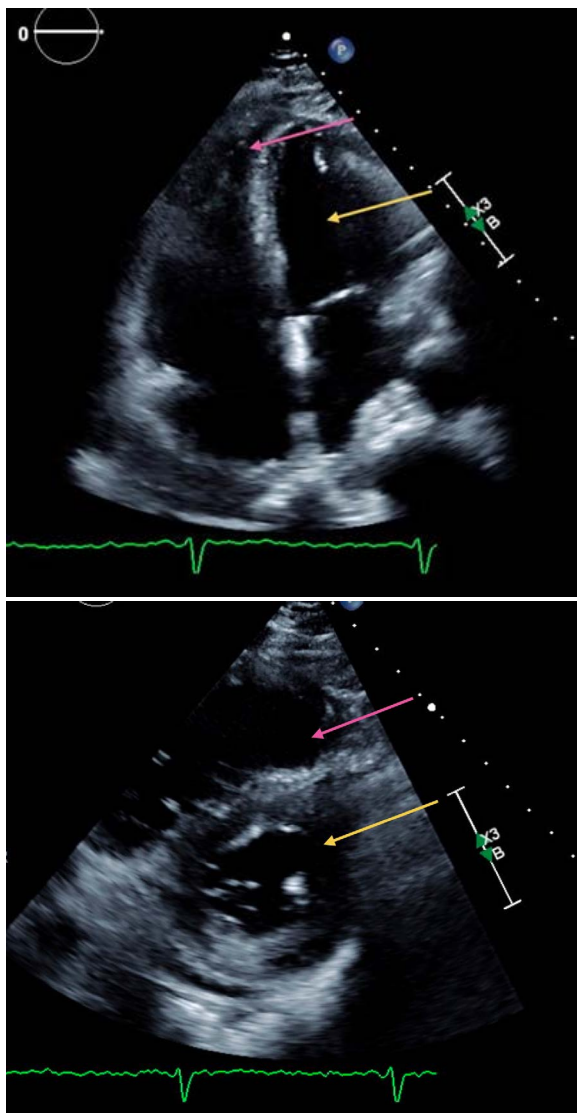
2D Echocardiogram, Apical 4 chamber view demonstrating enlarged right ventricle (pink arrow) compared to left ventricle (yellow arrow). As can be seen here, the majority of the apex in this view is dominated by right ventricle suggesting right ventricular overload.
